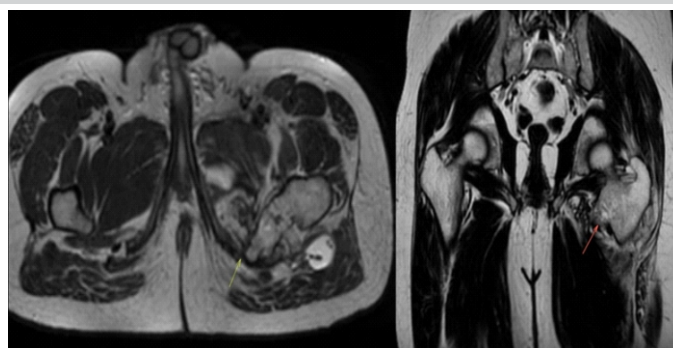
Axial and coronal sections of magnetic resonance imaging showing reduced ischiofemoral interval and growth from the lesser trochanter.
